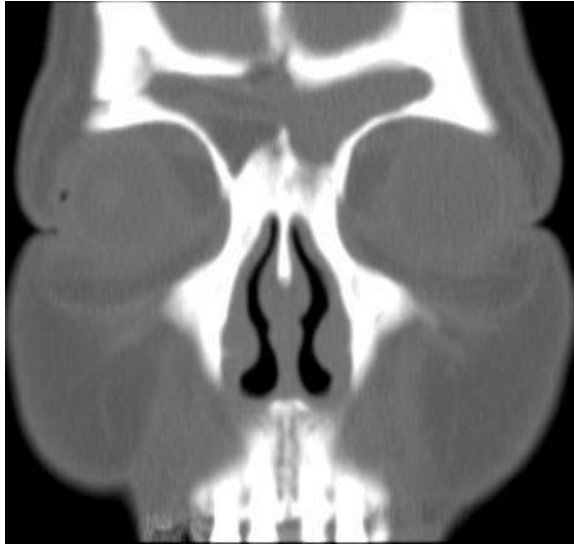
In coronal CT, a low-density soft tissue shadow in the frontal sinus and an incomplete bone structure on the right side of the frontal bone can be seen.
